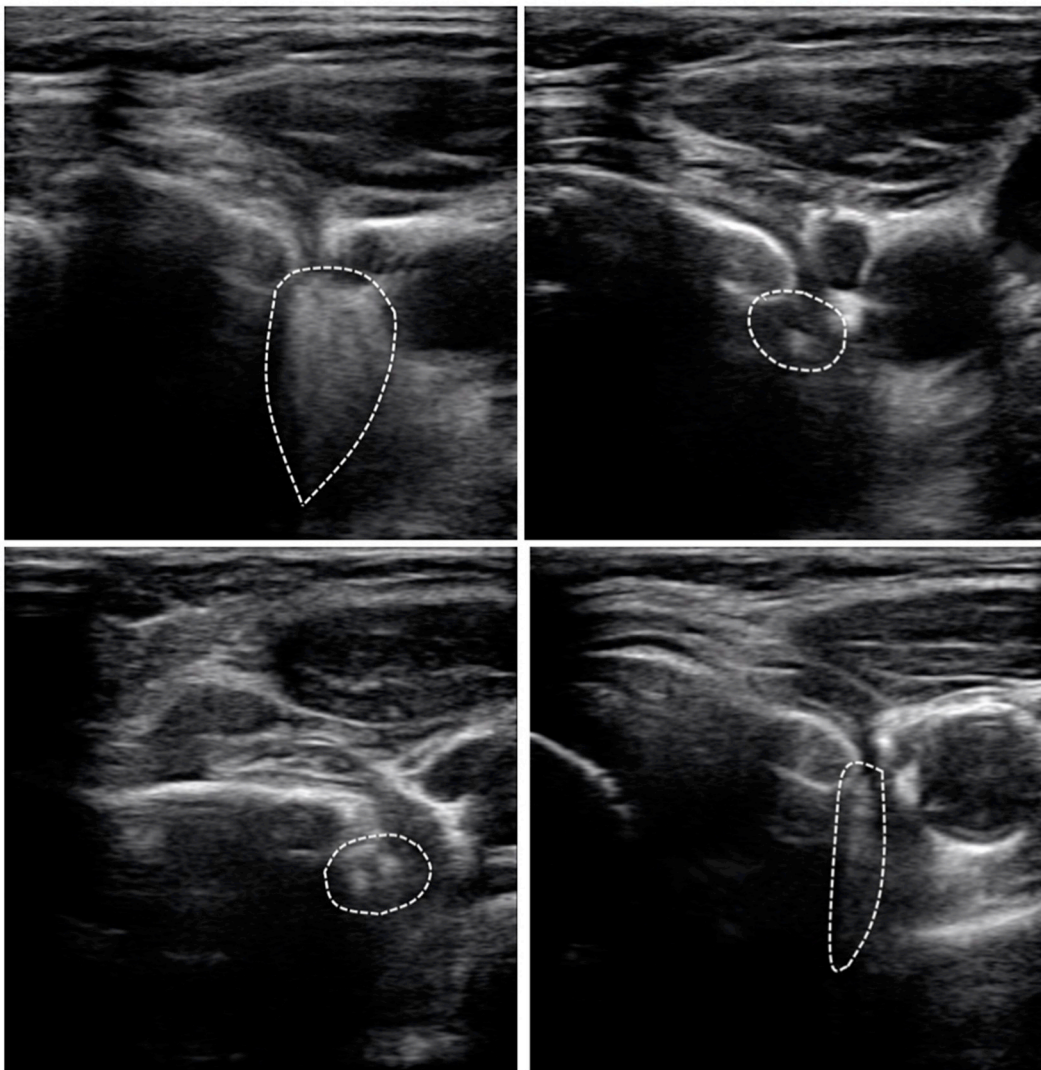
Images obtained during bag mask ventilation. (A) The dotted line outlines the air signal seen in the esophagus during a bag-delivered breath. (B) The dotted line outlines the esophagus between breaths. There is no air signal. (C) The dotted line outlines the esophagus with a small air signal during cricoid pressure. (D) The dotted line outlines the narrow air signal seen in the esophagus during ultrasound probe pressure.
